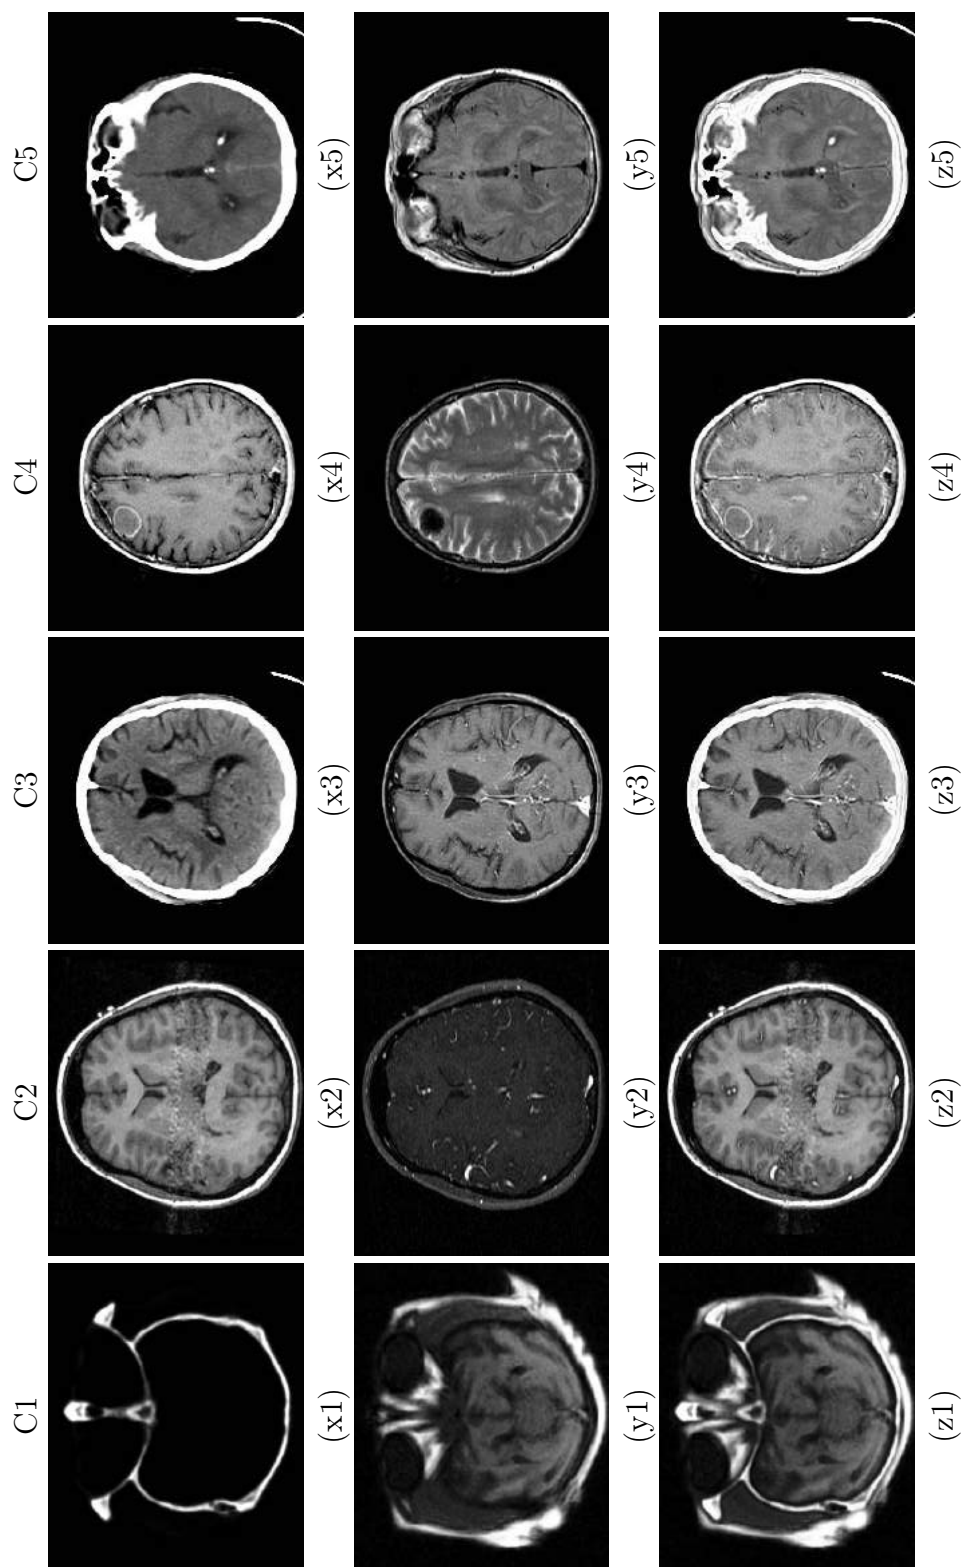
Source images (top two rows) with fusion results of 'Scheme 1' (last row): $x_1 = \text{CT}$, $y_1 = \text{MRI}$, $x_2 = \text{T1-weighted MR}$, $y_2 = \text{MR Angiography}$, $x_3 = \text{CT}$, $y_3 = \text{T1-weighted MR-GAD}$, $x_4 = \text{T1-weighted MR}$, $y_4 = \text{T2-weighted MR}$, $x_5 = \text{CT}$, $y_5 = \text{Proton Density (PD) weighted MR}$.
